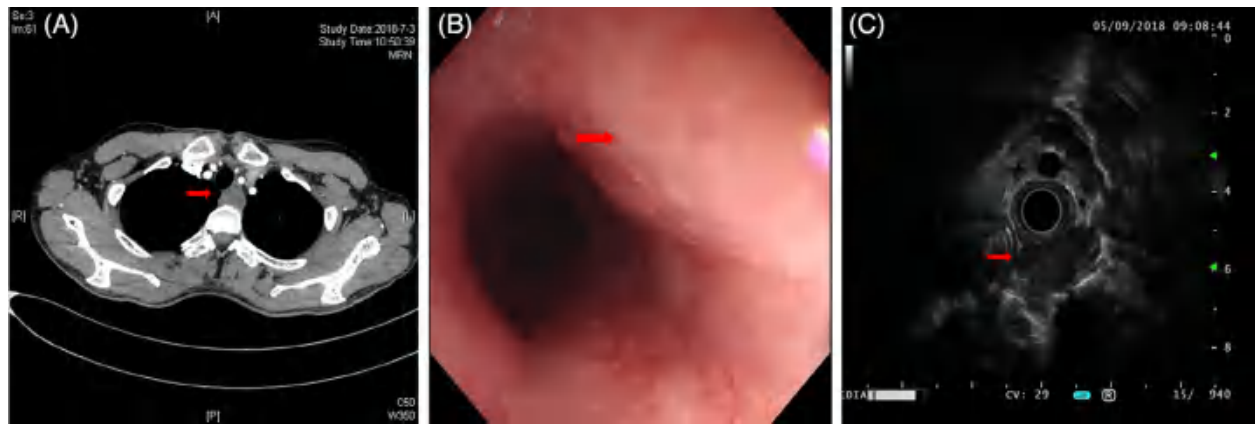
A, Contrast-enhanced chest computed tomography showed a round-shaped mass in the peritracheal posterior mediastinum. B, Gastroscopy revealed a protruded lesion in the esophageal midsection. C, EUS views of a mediastinal mass derived from upper posterior mediastinum, which is partly located close to the posterior wall of esophagus with hypoechogenicity
